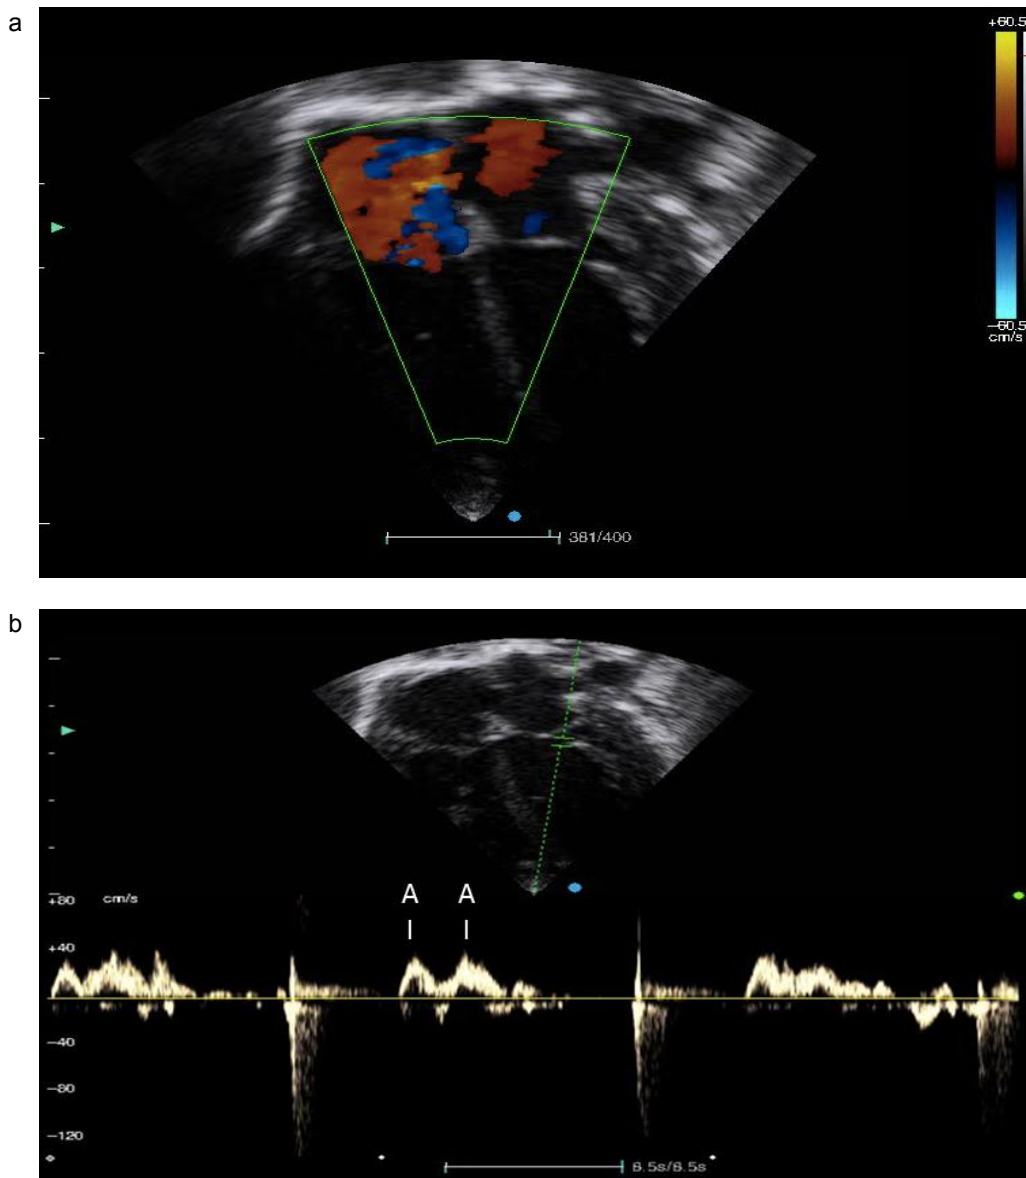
Fetal echocardiography, with evidence of four cardiac chambers without observed structural alterations (a); the newborn's PR interval of 8,500 milliseconds confirms the diagnosis of complete congenital atrioventricular block; A, atrial. (b).
